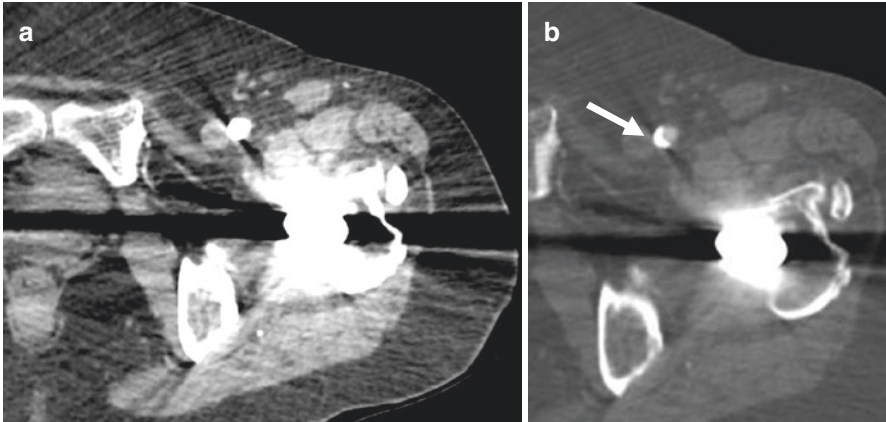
(a) CT angiography at the common femoral artery (CFA) level in the presence of a total hip replacement. Significant streak artefact due to beam hardening secondary to the metallic prosthesis is noted extending through the imaged CFA. At standard soft tissue window settings, the CFA appears widely patent with no disease. (b) Widening the window level to extend the grey scale increases the detail visible within the CFA and allows visualisation of medial calcified plaque (arrow) which is denser than contrast/blood mixture and also reduces the severity of streak artefact from the hip replacement
